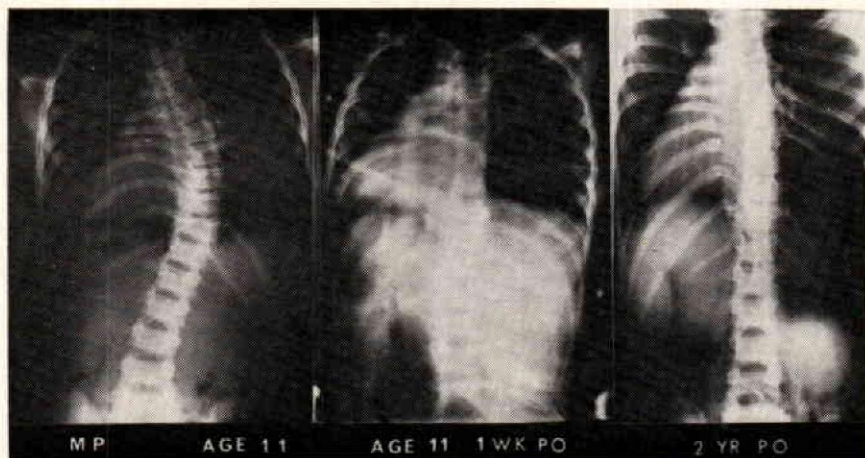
Typical scoliosis, surgically corrected, to which plastic laminated jacket was applied. (X-ray photo courtesy Darius Flinchum, M.D., Atlanta, Georgia.)
